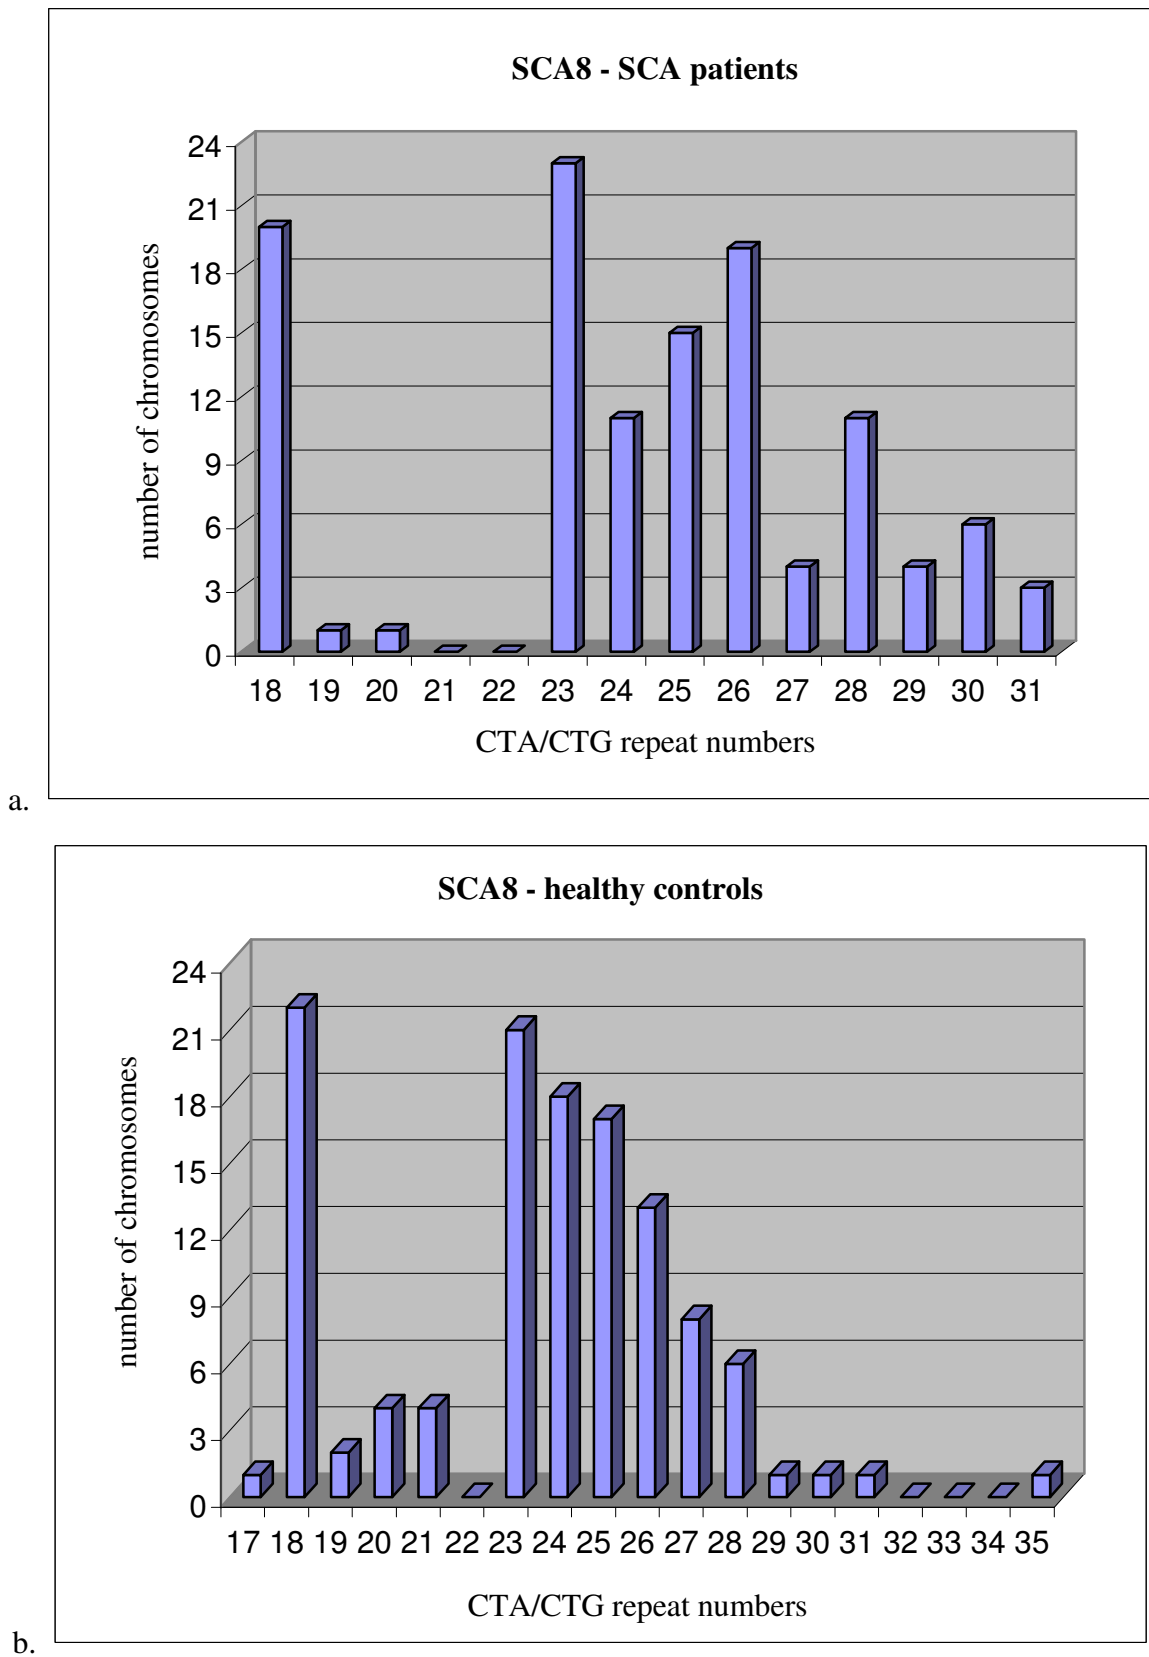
The distribution of SCA8 alleles with different CTA/CTG repeats among SCA patients (a) and healthy controls (b)
